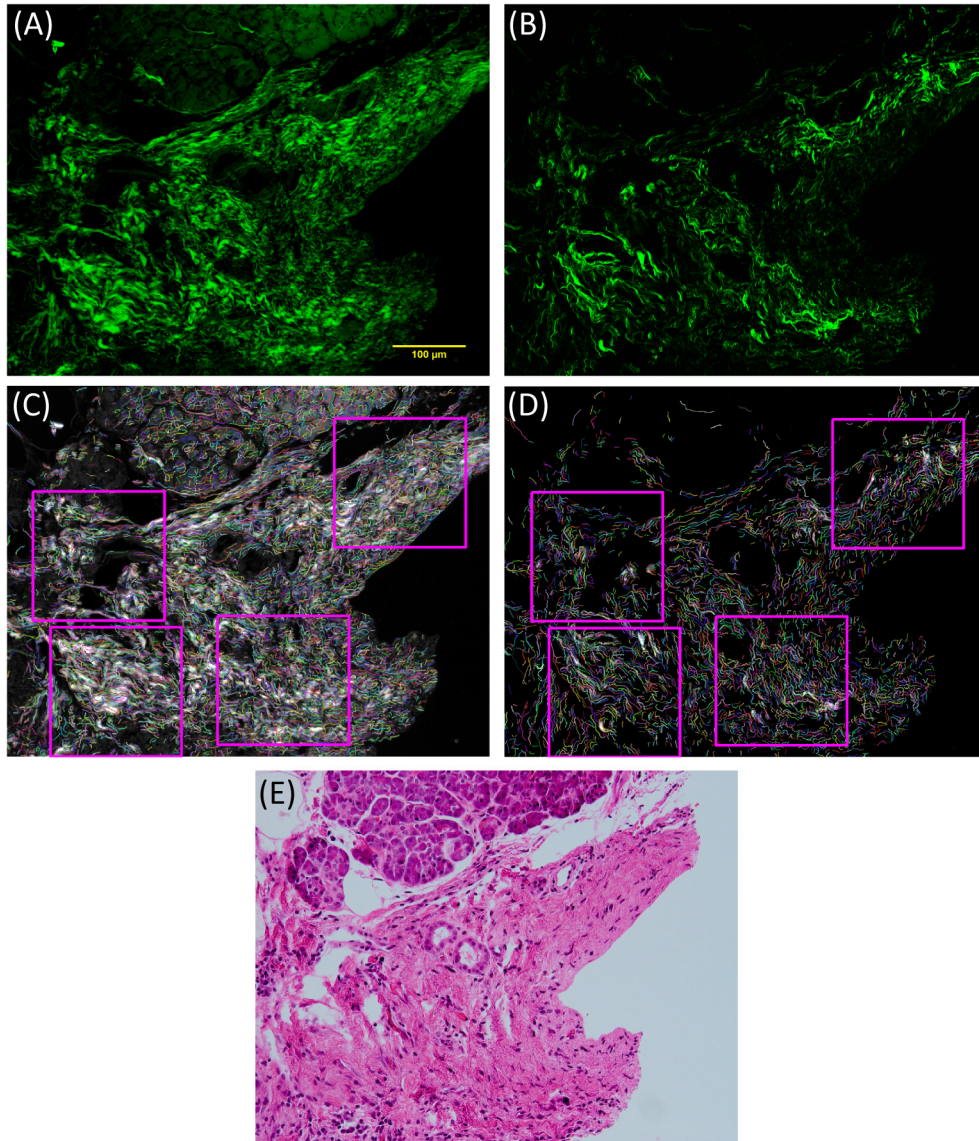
Comparison of PolScope and SHG imaging on pancreatic tissue slides. Pancreatic tissue sample imaged with PolScope (A) and SHG (B). The CT-FIRE fiber detection results and ROI selection for PolScope (C) and SHG (D). Part (E) shows the bright field image of the same region. The fibers in (C) and (D) are displayed in randomly selected false colors for visualization purpose. Brighter regions in (A) indicate thick or closely packed fibers.
